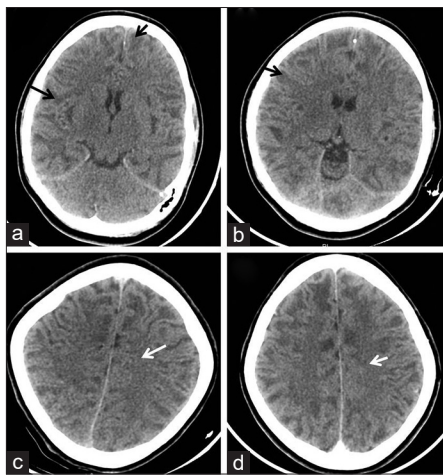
Axial noncontrast computed tomography head images showing diffuse hypodensities in the bilateral cerebral hemispheres (black arrow in a and b) with sparing of periventricular and deep white matter (white arrow in c and d)
